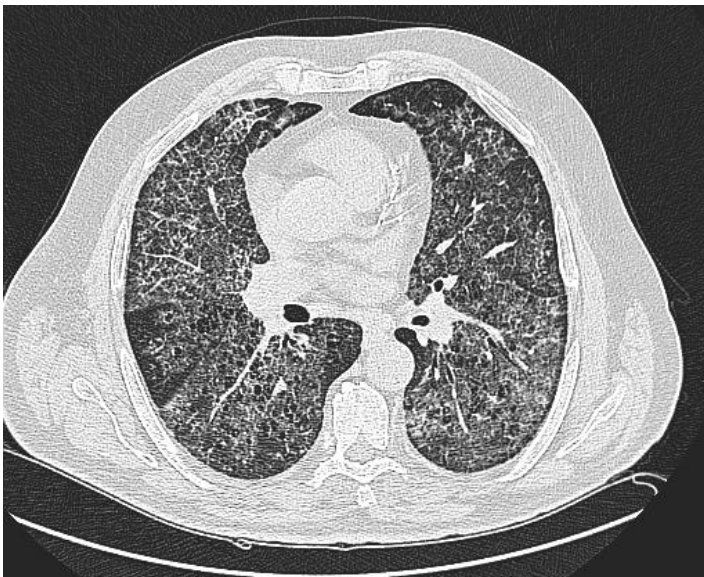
CT scan - Ground-glass opacities with thickened interlobular septa and intralobular lines bilaterally.
